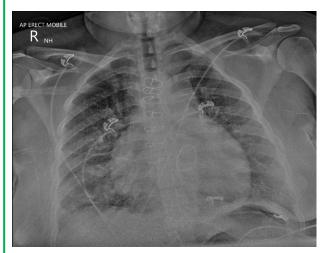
Chest X-ray on presentation to the emergency department demonstrating enlarged cardiac silhouette with cardiothoracic ratio of 0.57, sternal wires, previous valve replacement and features suggestive of pulmonary interstitial oedema.
